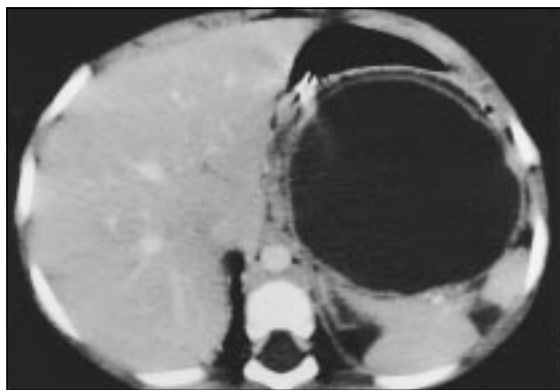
Giant pseudocyst seen on computed tomography several weeks after an acute episode of pancreatitis
